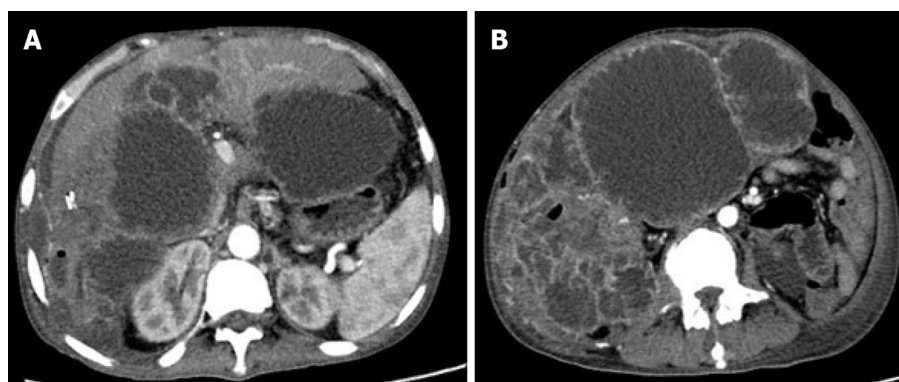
Magnetic resonance imaging at month 8 after the second surgery. A: Computed tomography enhanced arterial phase image showing intrahepatic and abdominal metastases; B: Computed tomography enhanced arterial phase image showing metastatic lesions presenting as multiple cystic masses with enhanced edges.
